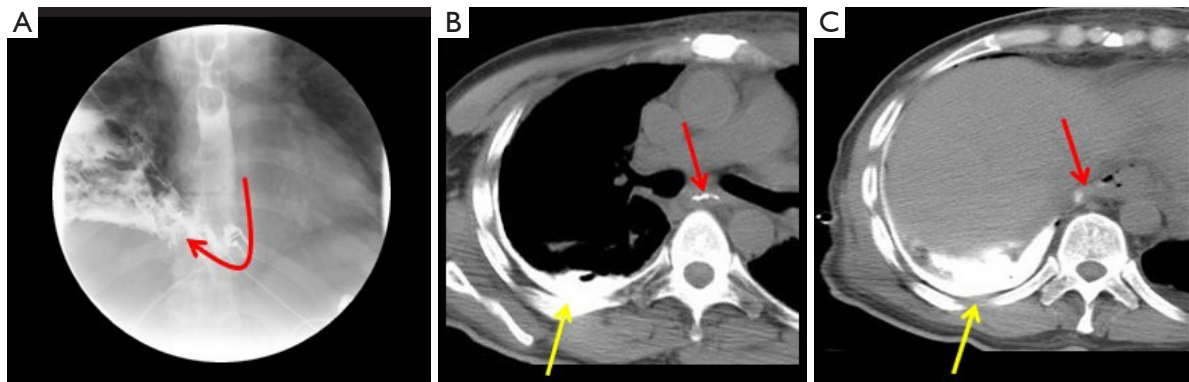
A 50-year-old man with esophageal rupture. (A) Fluoroscopic image showing a defect in the left esophageal wall with the red arrow pointing towards contrast tracking into the right pleural space. (B) Axial views of chest CT scan showing contrast in the esophagus (red arrow) and extravasation into the right pleural space (yellow arrow). (C) Axial views of chest CT scan showing contrast in esophagus (red arrow) and extravasation into the right pleural space (yellow arrow). CT, computed tomography.
